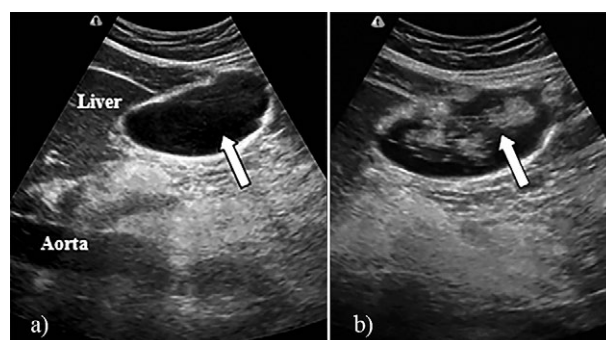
a) Ultrasound image before and b) after administration of contrast in stomach (white arrows).
